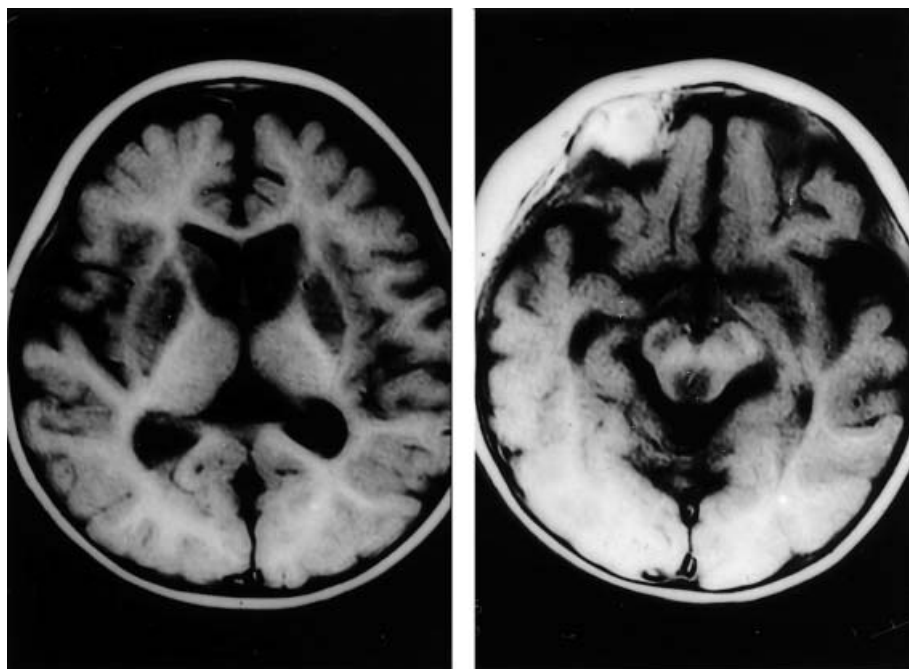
Cranial T₁-weighted magnetic resonance images at 10 months of age. Symmetrical lesions are present in the bilateral putamina, caudate nuclei, periaqueductal gray matter, and substantia nigra.
